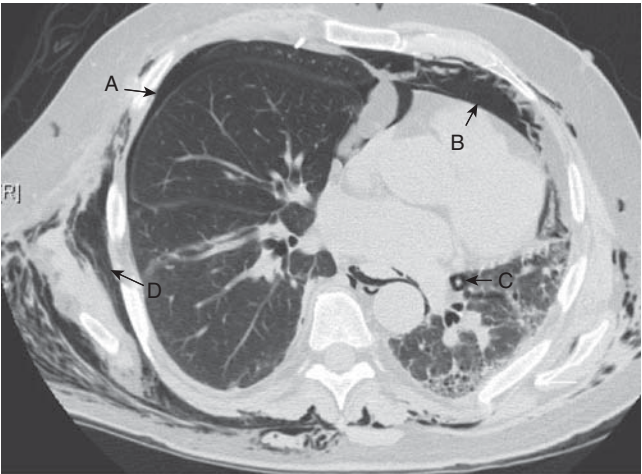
Computed tomography image through midchest showing multiple manifestations of pulmonary barotrauma in the same patient including: (A) pneumothorax; (B) pneumomediastinum; (C) pulmonary interstitial emphysema represented by a halo of air surrounding a vascular structure; and (D) subcutaneous emphysema.
